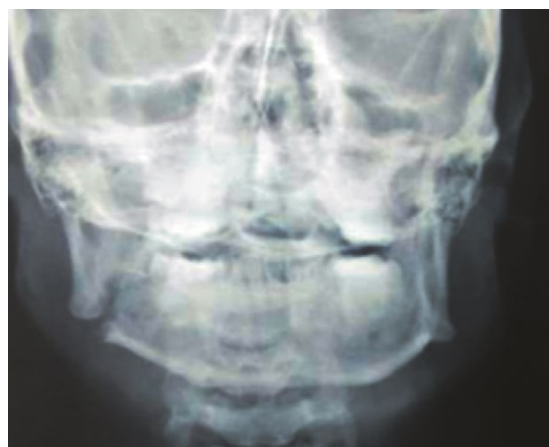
Orthopantomogram showed a fracture angle of the mandible on the right
